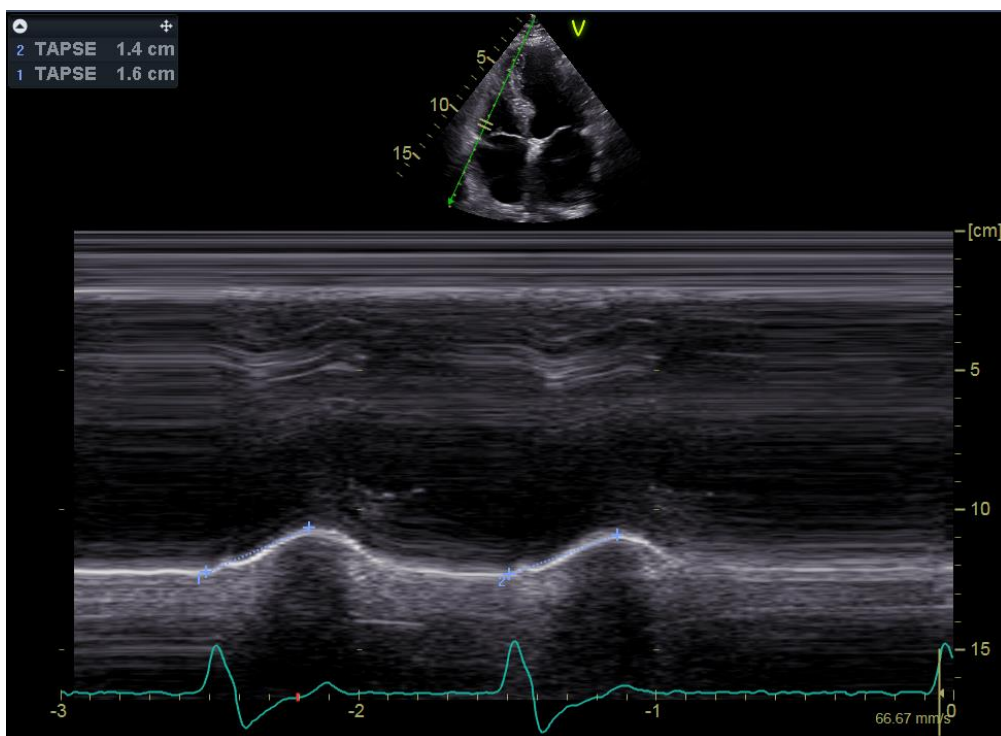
Echocardiographic measurement of tricuspid annular plane systolic excursion (TAPSE) using M-mode at the junction of the tricuspid valve plane with the free wall of the right ventricle.
